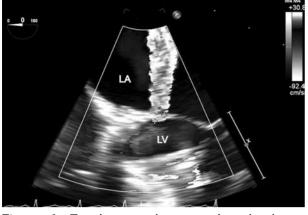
Two-dimensional transesophageal echocardiography shows 2 mm-leaflet perforation with moderate regurgitation on medial side of native mitral valve (plus). LA: Left atrium; LV: Left ventricle.
